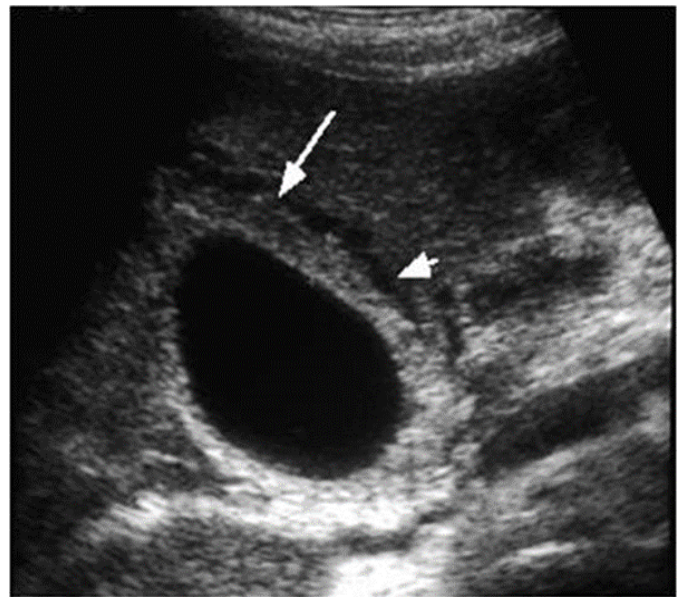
The ultrasound findings of a positive Murphy's sign: marked thickening of the gall bladder wall (arrow) with fluid surrounding the distended gall bladder (arrowhead). Courtesy: Jonathan Kruskal, MD.
